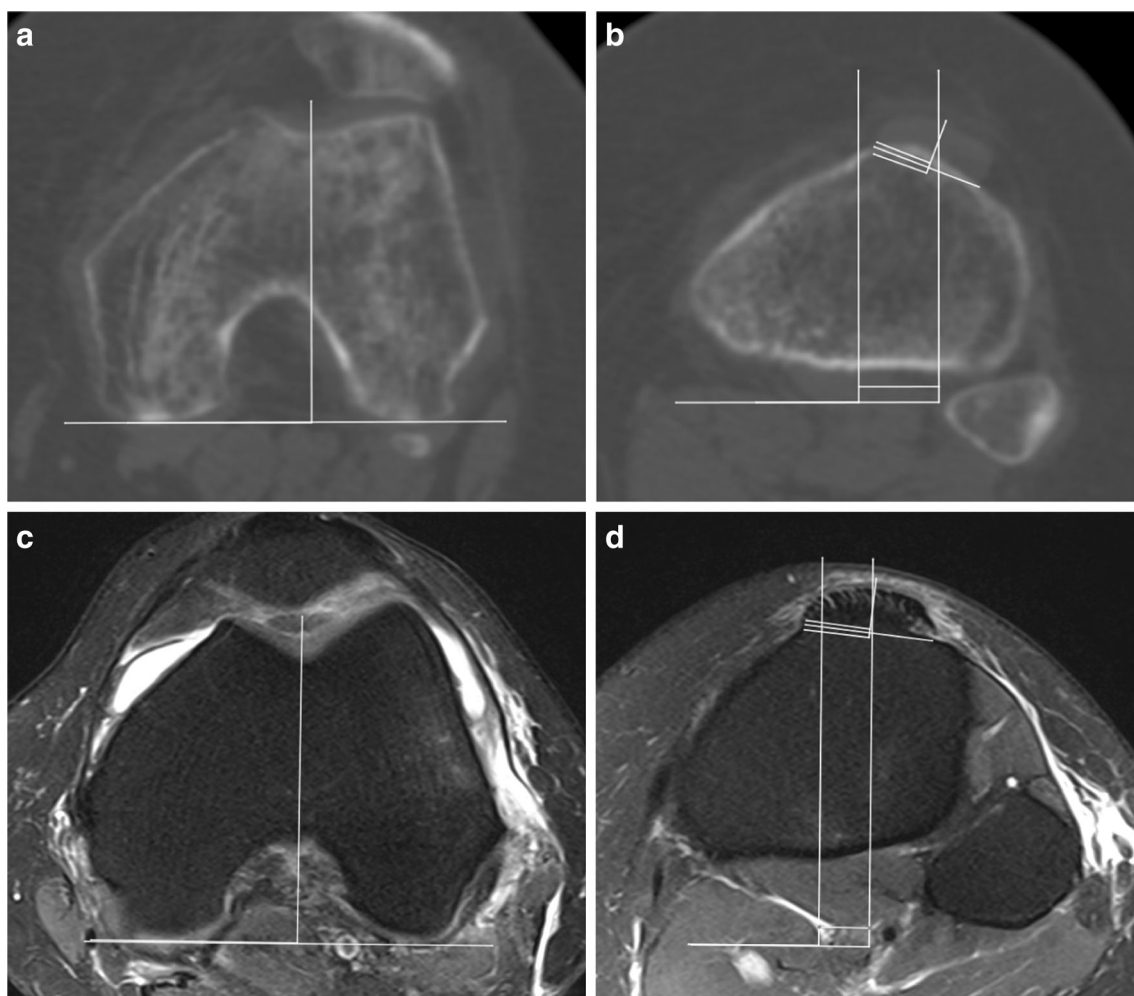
PT-TG on CT and PT-TG on MRI (images from different patients). a Cartilaginous and cartilaginous trochlear landmarks on CT; b: cartilaginous, cartilaginous trochlear, and patellar tendon landmarks and the PT-TG distance on CT; c: cartilaginous and cartilaginous trochlear landmarks on MRI; d: cartilaginous, cartilaginous trochlear, and patellar
